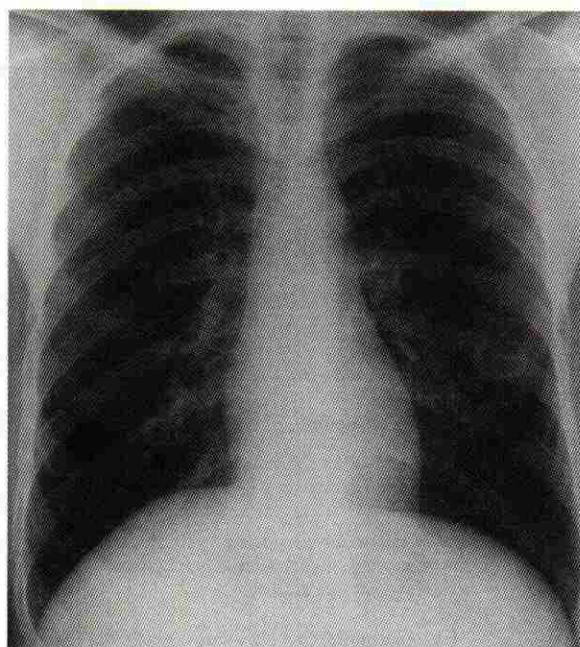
Posteroanterior chest radiograph shows a cystic lesion in the left mid lung due to coccidioidomycosis infection.
